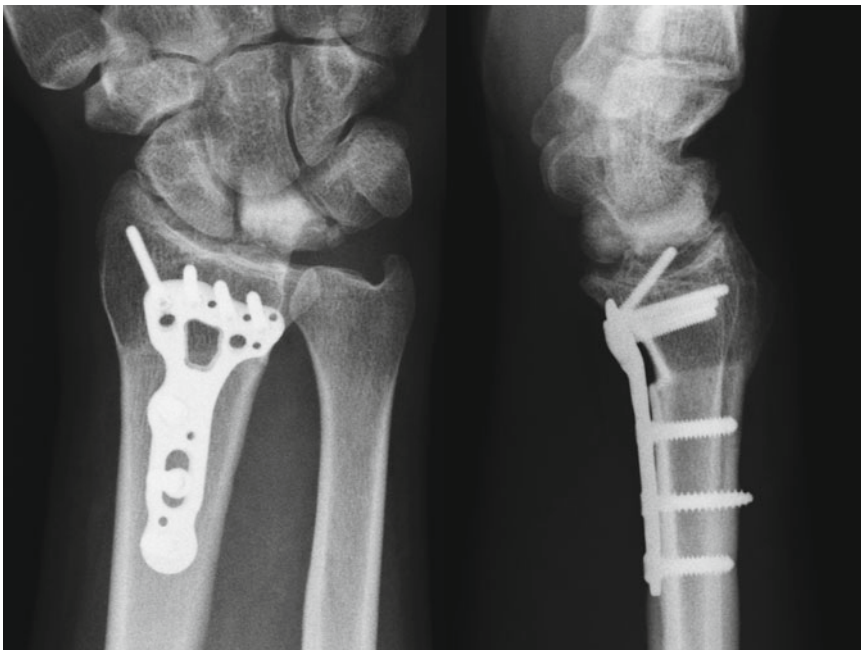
Postoperative plain X-ray. Osteotomy stabilized with a volar locking plate
